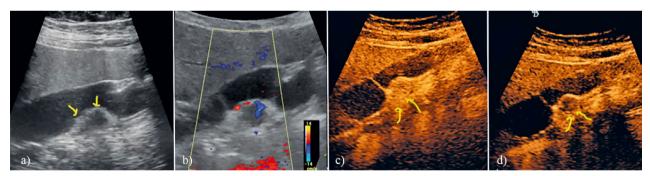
Cholecystic metastasis (ovarian carcinoma): a) grayscale (arrows); b) color Doppler; c) and d) CEUS exploration, arterial and venous phase (arrows) – highlighting loading and unloading with tumoral significance.
